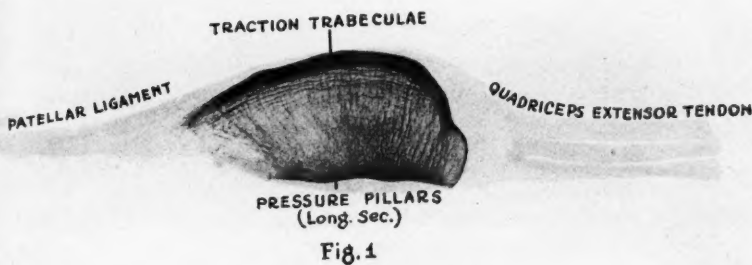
Fig. 1. Roentgenogram of human patella (mid-sagittal section). The traction trabeculae are on the ventral aspect of the patella in the direct line of traction of the tendon of the quadriceps extensor muscle and the patellar ligament. The pressure pillars are arranged at right-angles to the traction trabeculae and converge toward the dorsal or articular aspect of the patella. The articular cartilage is evident by its lighter-shadow-casting property (natural size).
